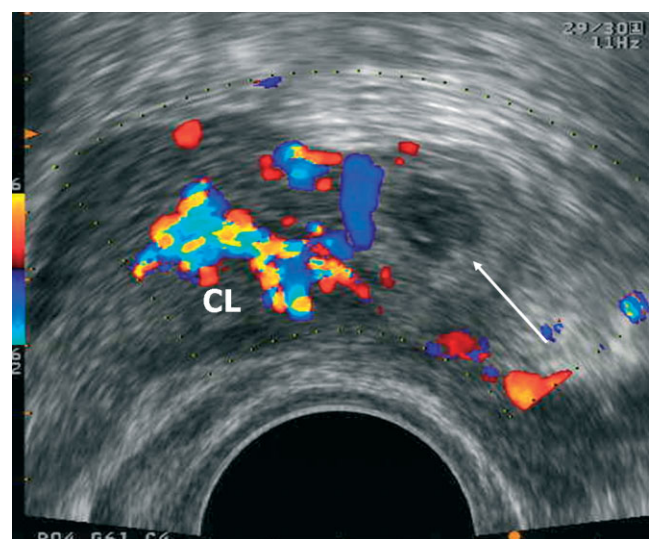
An image of a case of early ovarian pregnancy showing a gestational sac surrounded by ovarian stroma (arrow) and a solid corpus luteum (CL) with typical 'ring of fire' blood flow on Doppler examination.
